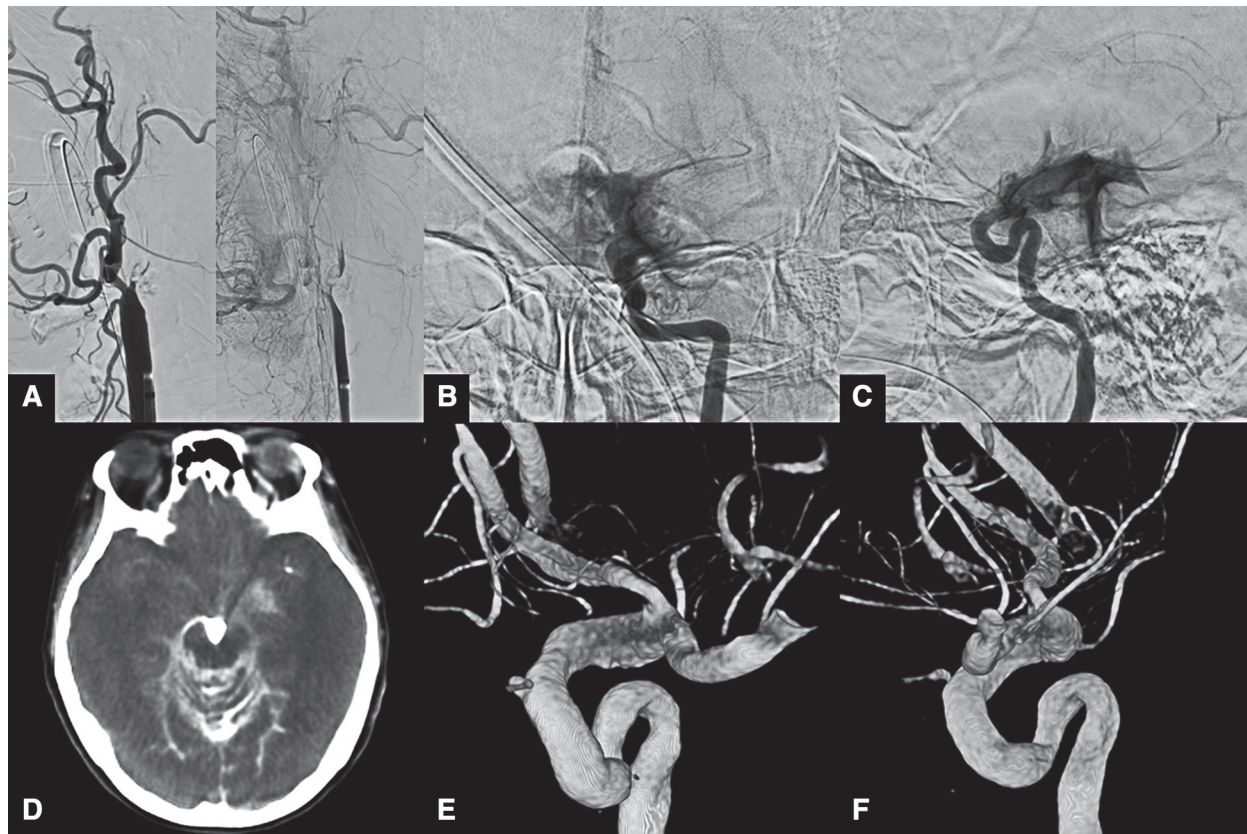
Pre- and intraoperative angiography. (A) Preoperative left carotid angiography showed severe stenosis of the ICA at the level of its bifurcation. (B and C) Initial left ICA angiography after advancing the 5MAX ACE showed active bleeding into the subarachnoid space from the C2 segment of the left ICA. (D) Cone beam CT during the procedure revealed leakage of contrast medium and diffuse SAH. (E and F) 3D angiography revealed irregular dilatation at the C1 and C2 segments of the left ICA, suggesting dissection. ICA: internal carotid artery; SAH: subarachnoid hemorrhage
